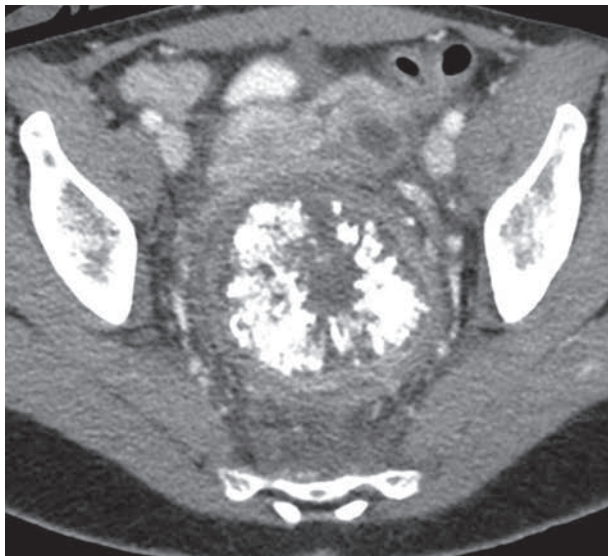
Axial contrast enhanced CT image (L : -10 HU ; W : 386 HU) five months later after neoadjuvant chemo-radiotherapy. Note the global stability of the mass but an important increase in its mineralized component.
